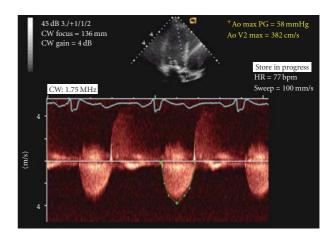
Doppler echocardiogram of the aortic valve (done in 2005) shows moderate aortic stenosis and aortic regurgitation in a 46-year-female who had received radiation therapy for Hodgkin's disease in 1976. Some degree of regurgitation was noted in all 4 valves
